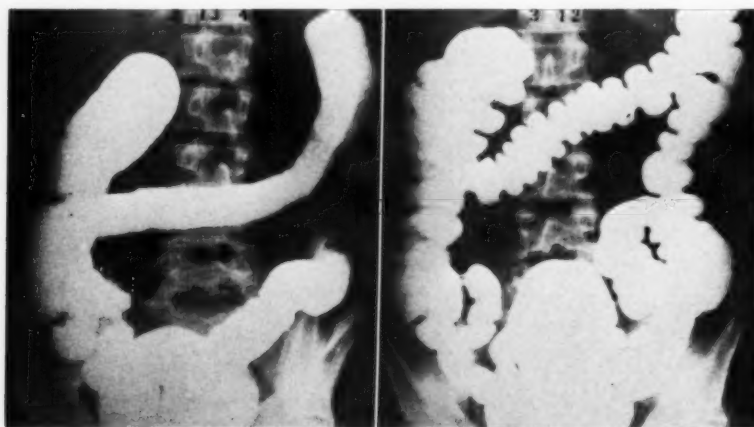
Y. T. Dramatic reversal of roentgen changes of ulcerative colitis.
